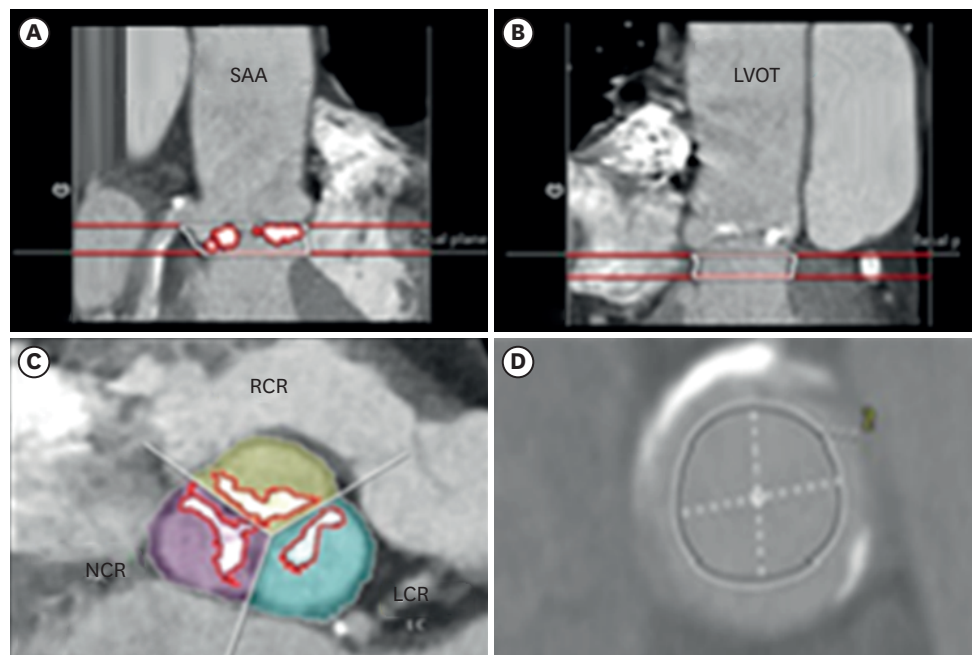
Multislice computed tomography aortic root dimensions. Multiplanar reconstruction views demonstrating the areas of interest. (A) SAA; (B) LVOT; (C) NCR, RCR and LCR; (D) Homogenous blood pool surface 10 mm above the ostium of the first coronary that branches of. LCR: left coronary cusp region, LVOT: left ventricular outflow tract, NCR: non coronary cusp region, RCR: right coronary cusp region, SAA: supra-annular area.
